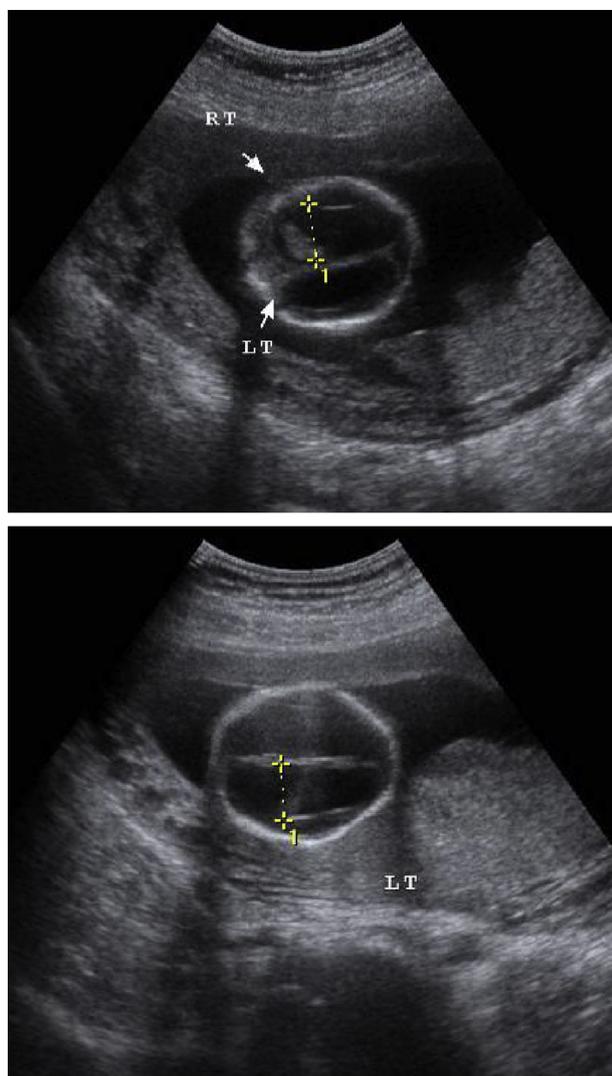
Transabdominal sonogram reveals bilateral ventriculomegaly (arrows). (Right ventricle is 1.45 cm, and left ventricle is 1.37 cm, respectively).
